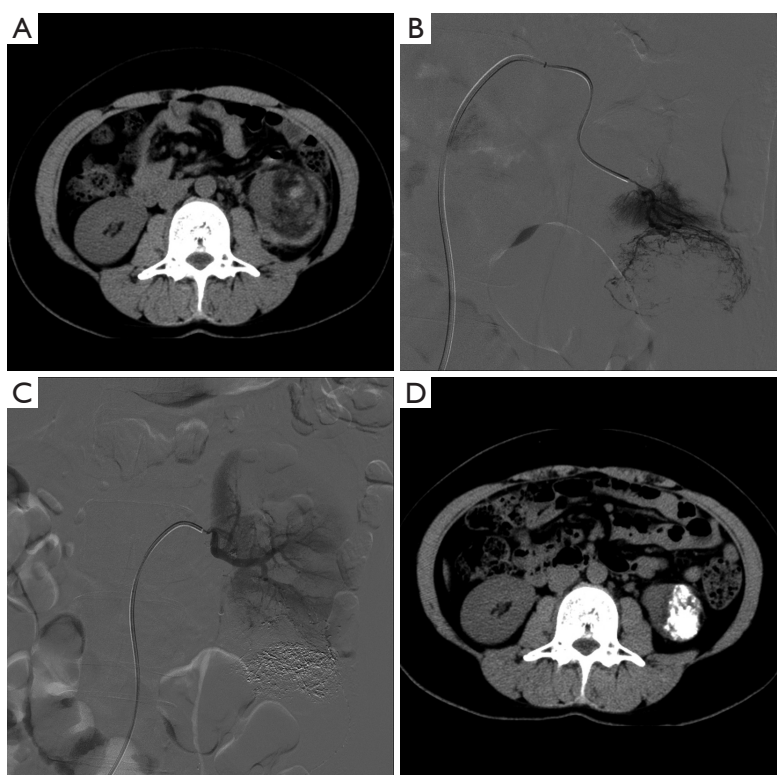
Renal angiomyolipoma embolized with a mixture of lipiodol and PVA in a 33-year-old female who presented with hematuria. (A) Pre-operative CT shows renal angiomyolipoma with hemorrhage in the lower pole of the left kidney; (B) angiogram demonstrates abnormal vascularity in the lower pole; (C) post-embolization angiography shows the lipiodol remaining in the lesion and the abnormal vascularity was eliminated; (D) CT obtained three months after embolization reveals lipiodol retained in the shrinking tumor. PVA, polyvinyl alcohol; CT, computed tomography.
